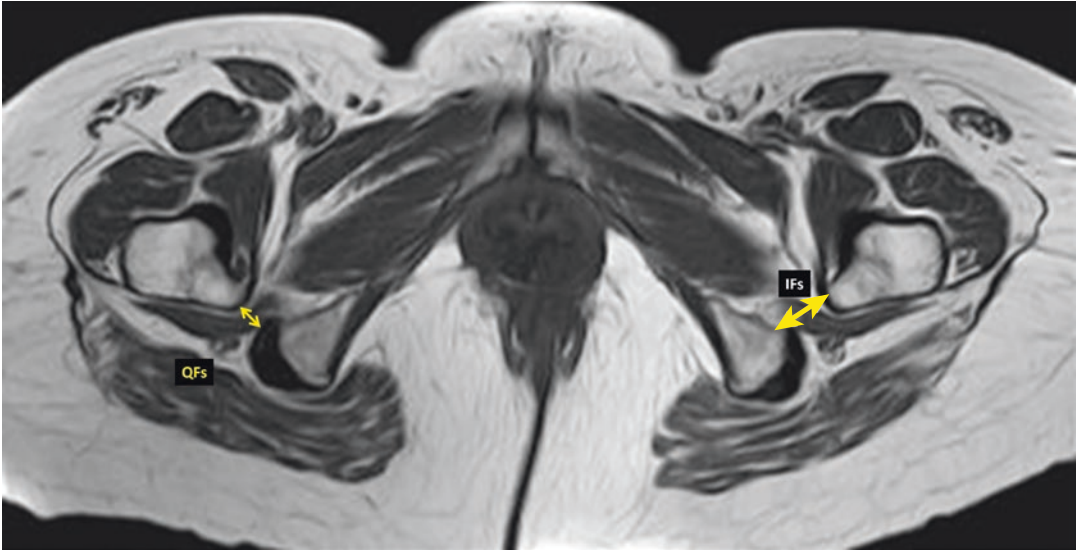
MRI T1 axial image showing IFs and QFs distances
